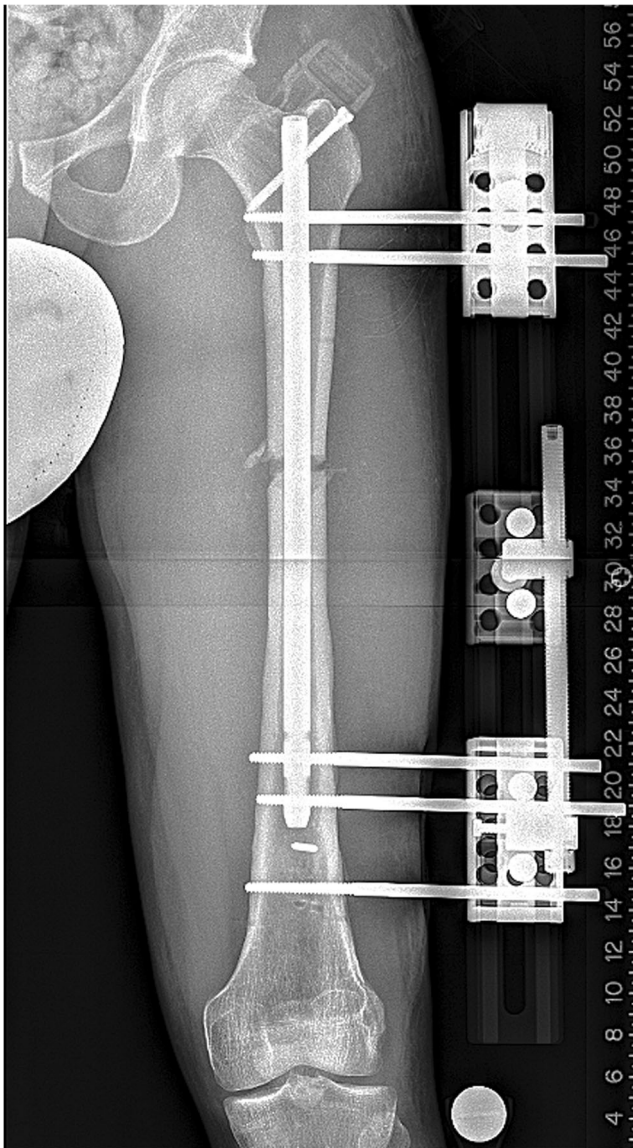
This AP radiograph shows a typical LON setup with the monolateral frame mounted parallel to the intramedullary nail and as close to the skin as safely possible.
